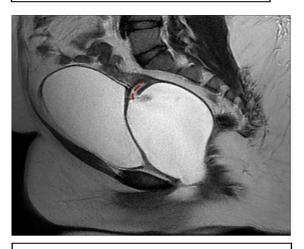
Sagittal T2W MRI Image shows bladder anteriorly and diverticulum posteriorly with RED dotted line showing fistulous communication of urethral diverticulum with the anterior vaginal fornix.
